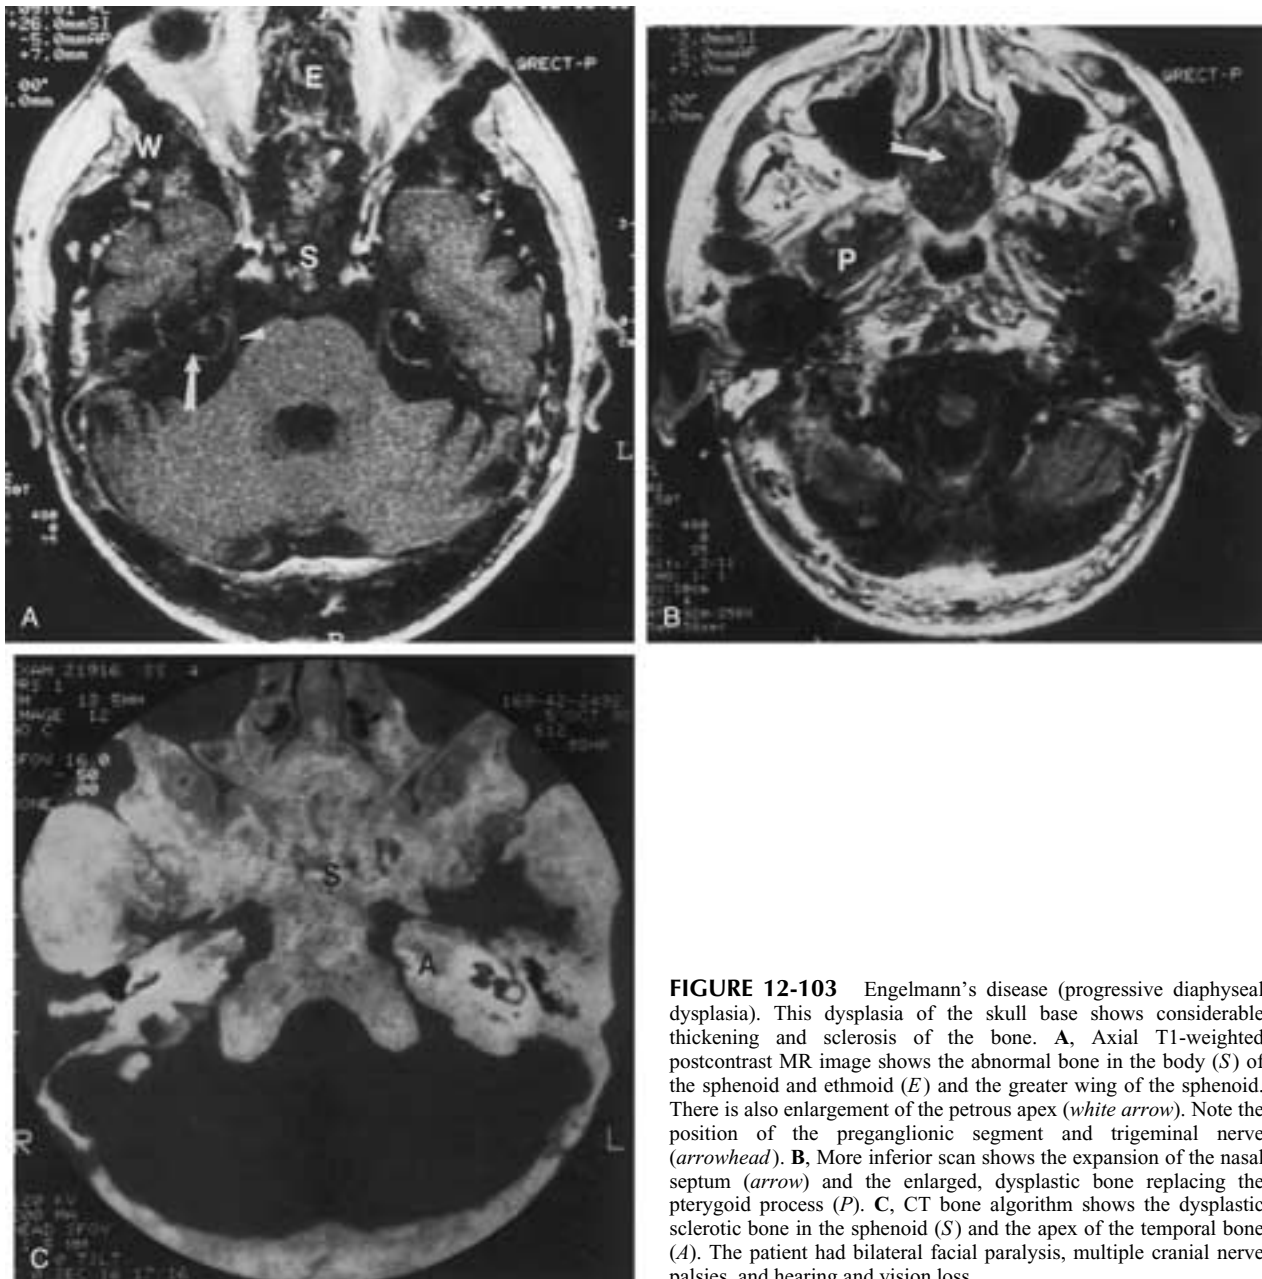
Engelmann's disease (progressive diaphyseal dysplasia). This dysplasia of the skull base shows considerable thickening and sclerosis of the bone. A, Axial T1-weighted postcontrast MR image shows the abnormal bone in the body (S) of the sphenoid and ethmoid (E) and the greater wing of the sphenoid. There is also enlargement of the petrous apex (white arrow). Note the position of the preganglionic segment and trigeminal nerve (arrowhead). B, More inferior scan shows the expansion of the nasal septum (arrow) and the enlarged, dysplastic bone replacing the pterygoid process (P). C, CT bone algorithm shows the dysplastic sclerotic bone in the sphenoid (S) and the apex of the temporal bone (A). The patient had bilateral facial paralysis, multiple cranial nerve palsies, and hearing and vision loss.
